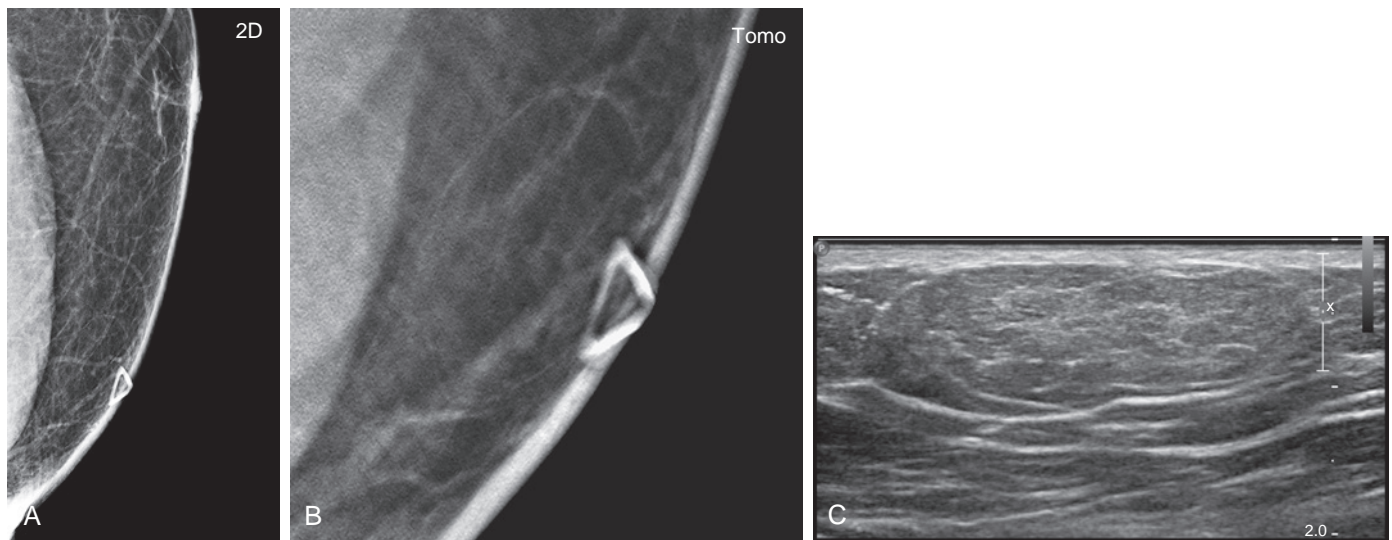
Lipoma. A 59-year-old man presents with a palpable lump in the lower inner left breast. (A) Two-dimensional mammogram shows only fatty tissue. (B) Tomosynthesis slice view reveals a thin capsule surrounding a fat-density lesion. (C) Although not necessary for diagnosis, ultrasound shows a corresponding slightly hyperechoic, wider-than-tall, oval mass, confirming the lipoma.
